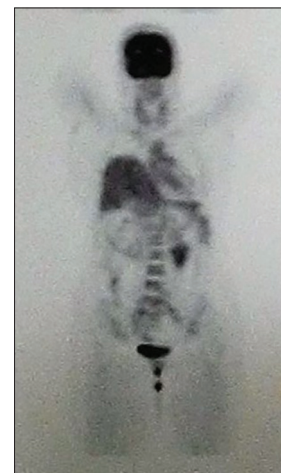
Positron emission tomography–computed tomography image showing pulling up of the right hemidiaphragm
